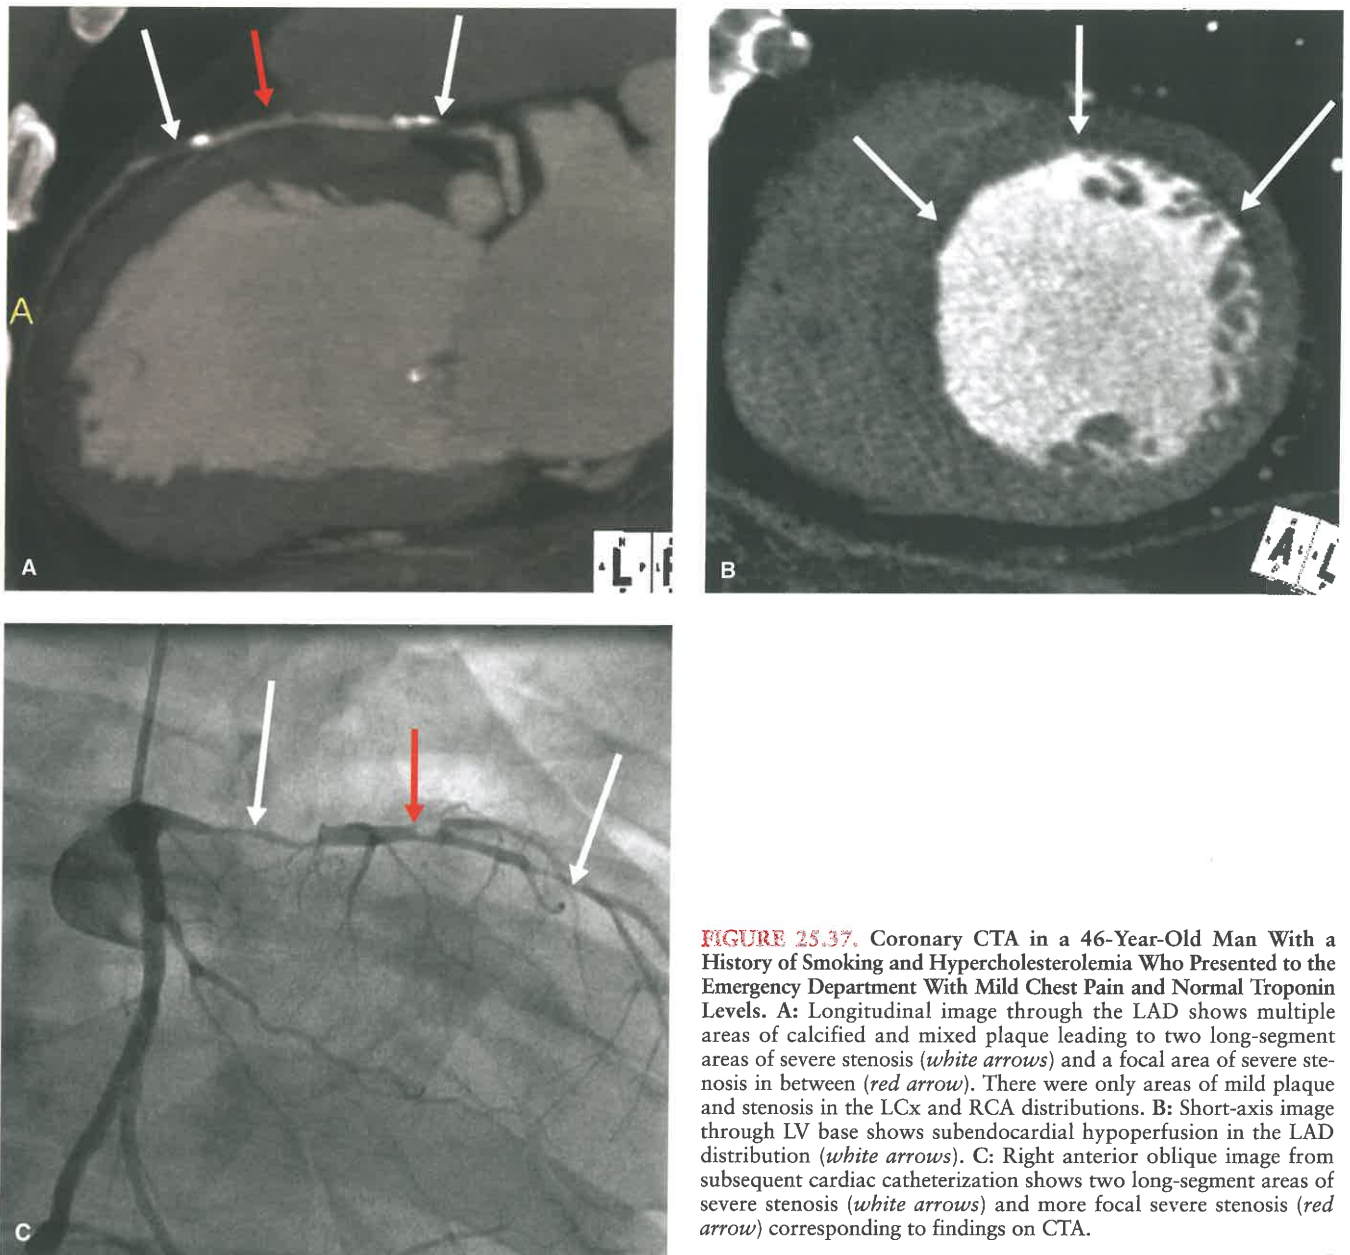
Coronary CTA in a 46-Year-Old Man With a History of Smoking and Hypercholesterolemia Who Presented to the Emergency Department With Mild Chest Pain and Normal Troponin Levels. A: Longitudinal image through the LAD shows multiple areas of calcified and mixed plaque leading to two long-segment areas of severe stenosis (*white arrows*) and a focal area of severe stenosis in between (*red arrow*). There were only areas of mild plaque and stenosis in the LCx and RCA distributions. B: Short-axis image through LV base shows subendocardial hypoperfusion in the LAD distribution (*white arrows*). C: Right anterior oblique image from subsequent cardiac catheterization shows two long-segment areas of severe stenosis (*white arrows*) and more focal severe stenosis (*red arrow*) corresponding to findings on CTA.
